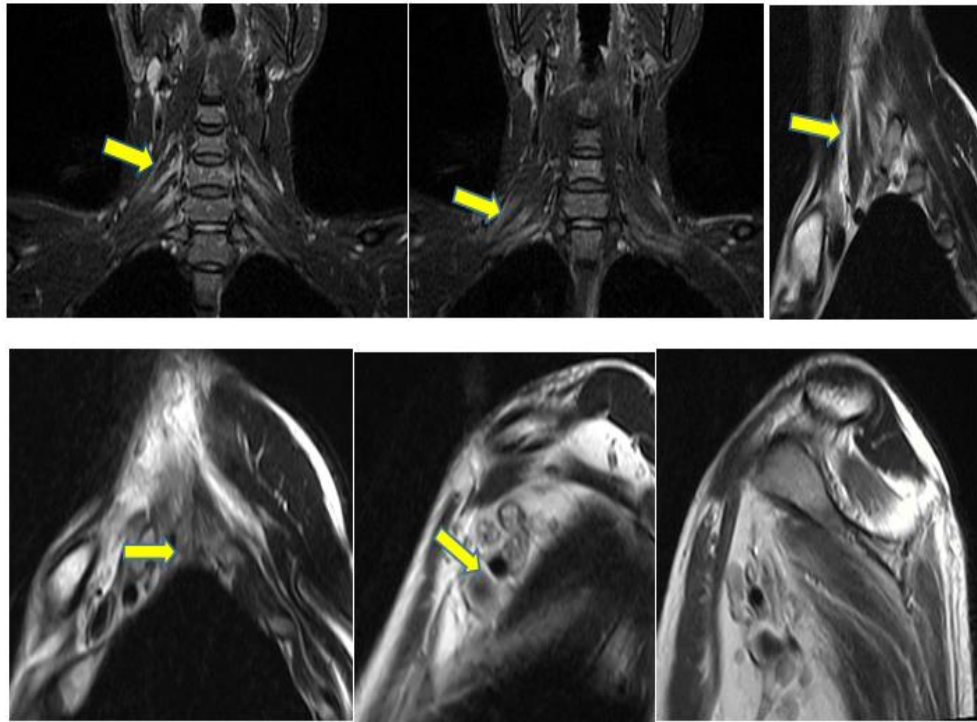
Normal MRI anatomy of brachial plexus. A. STIR coronal: Trunks B. STIR coronal: Divisions. C. Interscalene triangle. brachial plexus between anterior and medial scalene muscles. D. Sagittal oblique T2 – costoclavicular space, brachial plexus lies anterior to subclavicular vein. E. Sagittal oblique T2 at midclavicle are cords. F. Retropectoral minor space- cords and terminal branches (yellow arrow).
